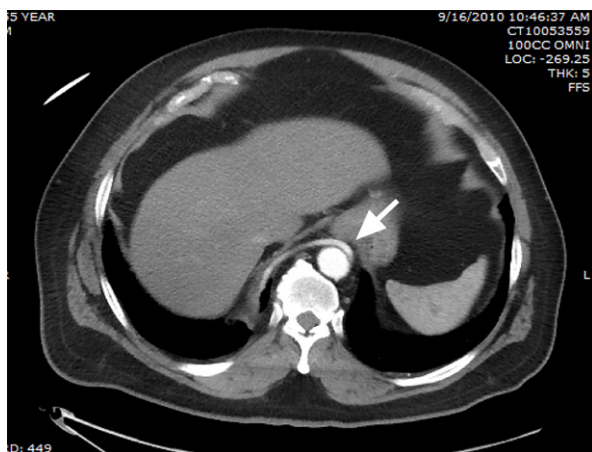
Patient 1. Computed tomographic angiogram shows an arterial branch (arrow) that arises from the infradiaphragmatic aorta and supplies the intralobar sequestrum.
